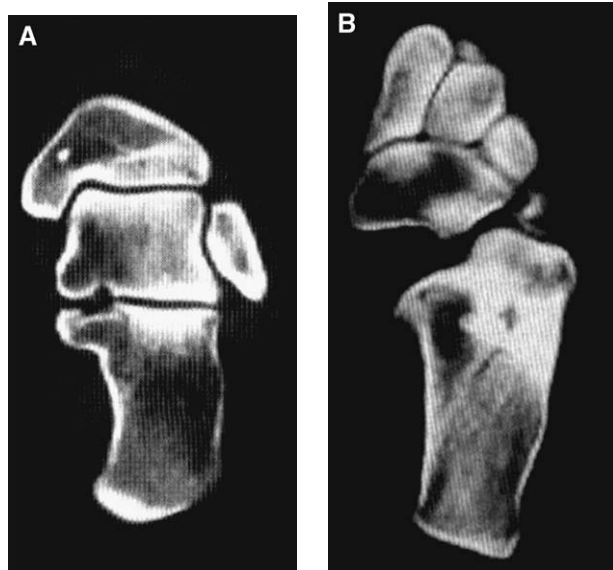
(A) A coronal CT slice showing the posterior articular facet and varus or valgus alignment of the heel. (B) An axial CT slice depicting the calcaneocuboid joint and lateral wall of the calcaneus.
